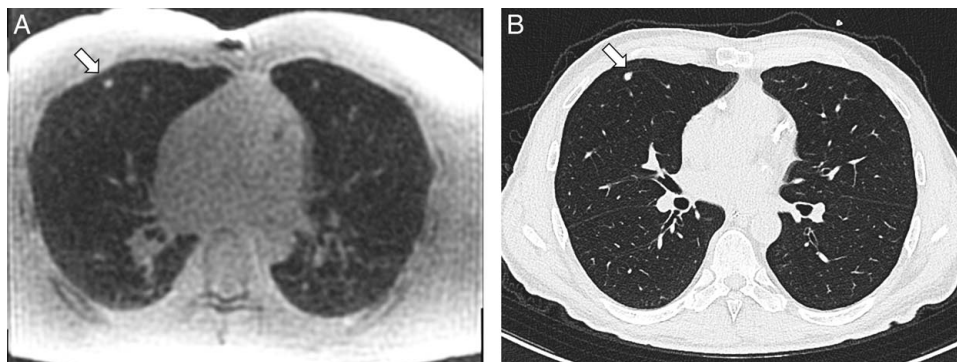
A 21-year-old male with incidentally detected pulmonary nodule. A, Axial nonenhanced T1-weighted Zero TE MRI shows a 5 mm pulmonary nodule (arrow) in the right upper lobe. B, Axial nonenhanced lung window setting CT image shows the 5 mm pulmonary nodule (arrow) in the right upper lobe with appearance very similar to MRI.
